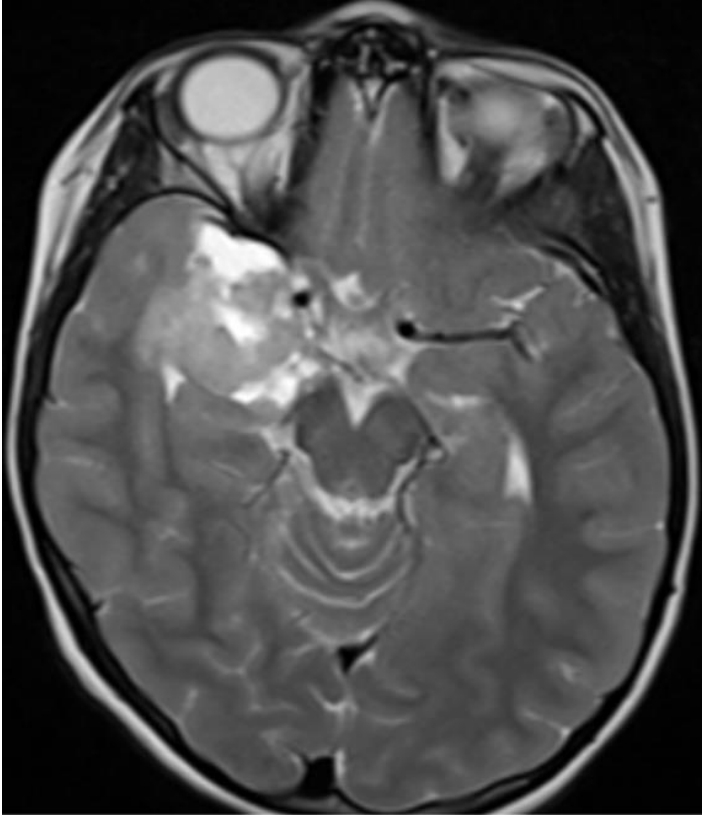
Magnetic resonance imaging scan showing an area with contrast enhancing in the right temporal region
